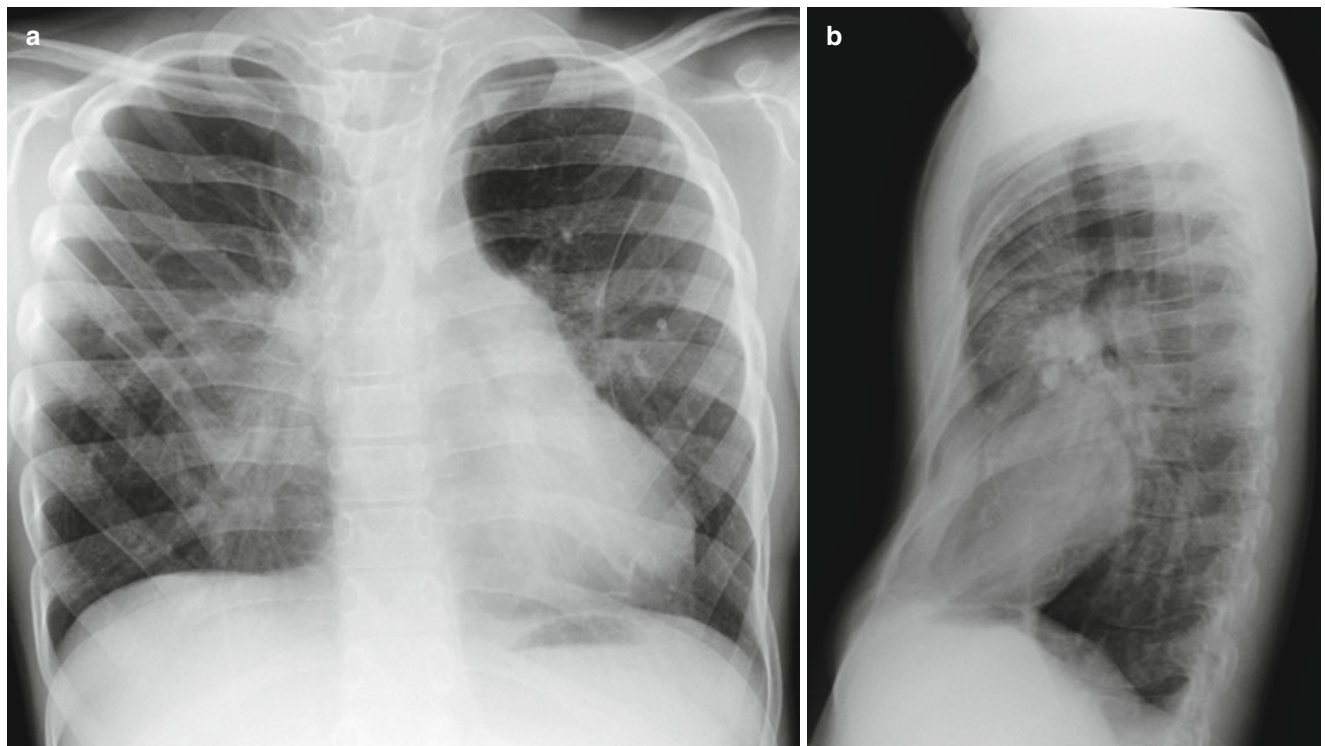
ABCA3 mutation in a 5-year-old boy. (a) Frontal chest radiograph shows increased coarse interstitial opacities in both lungs. (b) Lateral chest radiograph demonstrates a pectus excavatum
